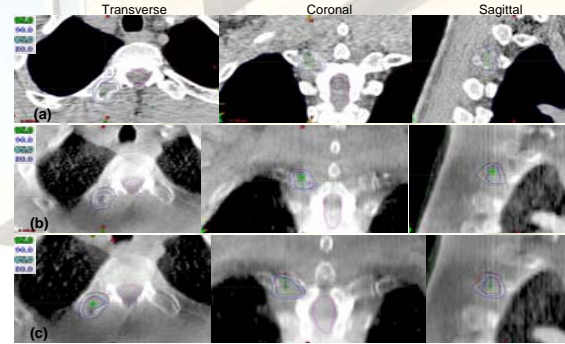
Comparison of the dose distributions of the target and spinal cord for case 1: (a) planned isodoses; (b) calculated isodoses based the CBCT acquired before treatment; (c) calculated isodoses based the CBCT acquired after treatment.
